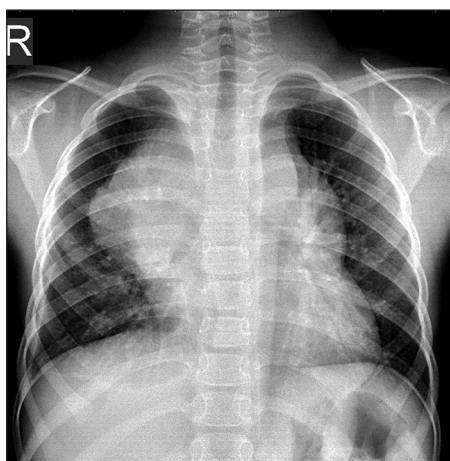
Preprocedure chest radiograph depicting mediastinal mass
